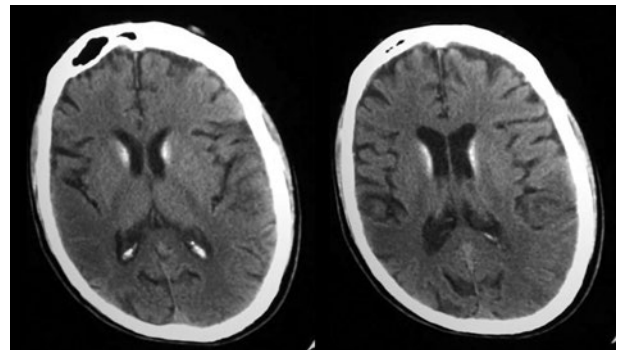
Axial computed tomography with symmetric calcifications in caudate nucleus.
